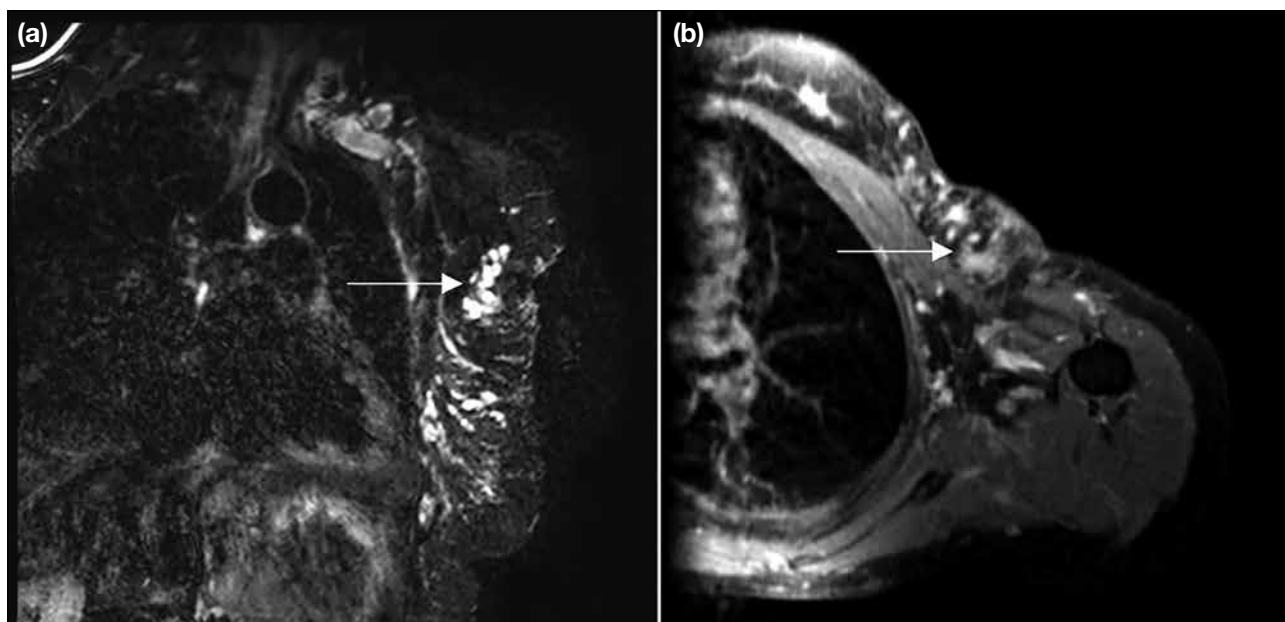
Venolymphatic malformation. Magnetic resonance images of the left chest wall. (a) T2-weighted coronal image with fat saturation and (b) T1-weighted axial image with fat saturation after gadolinium injection. Multiple clusters of lobulated T2-weighted hyperintense structures (arrow in [a]) with post-contrast enhancement are seen in the left breast (arrow in [b]).
